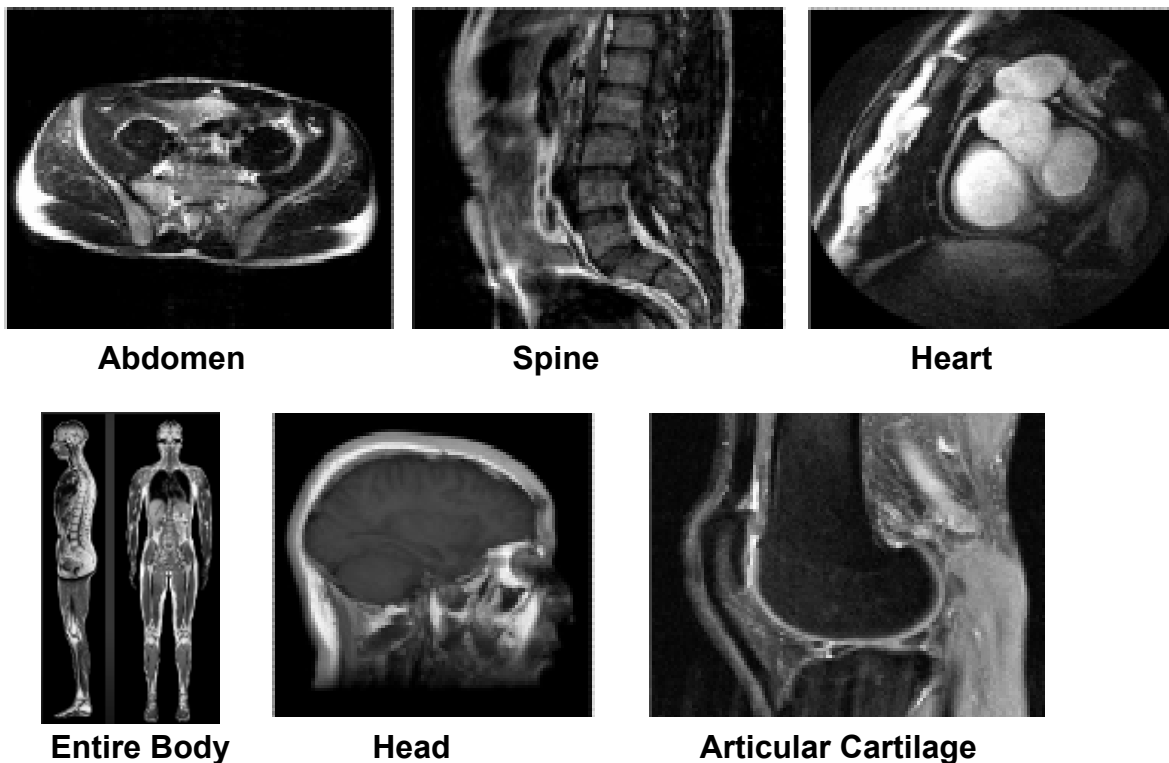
MRI scan of human abdomen, spine, head, entire body, head and articular cartilage.^{178,179}
